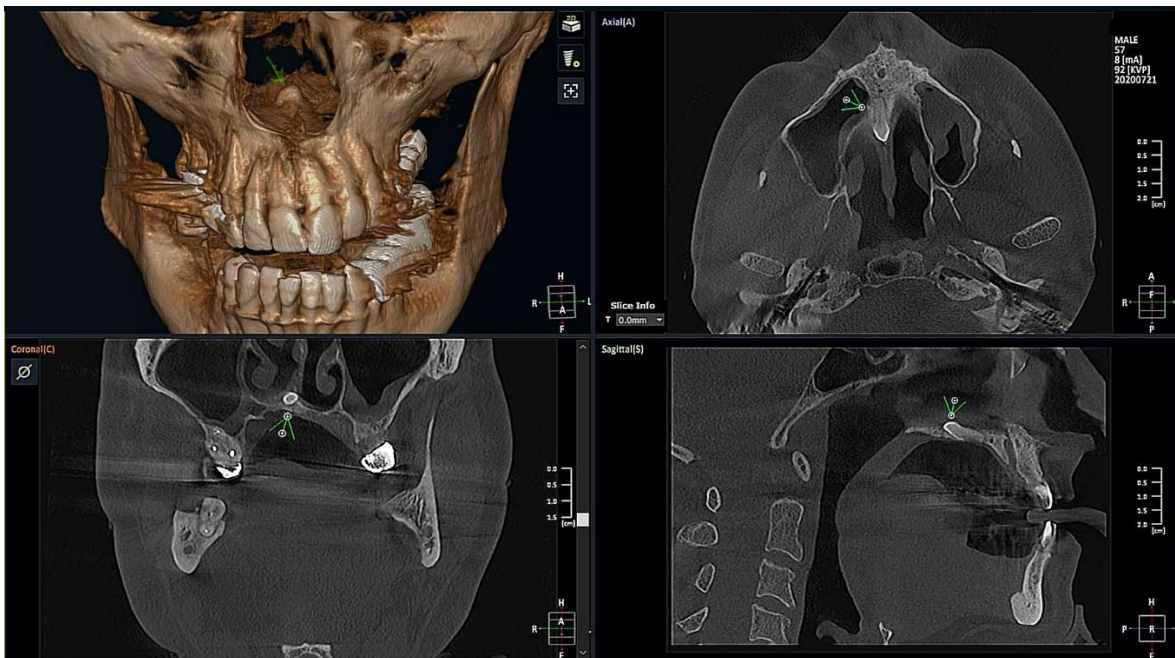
CBCT images of the mesiodens within the mid-palatal region in case #3
